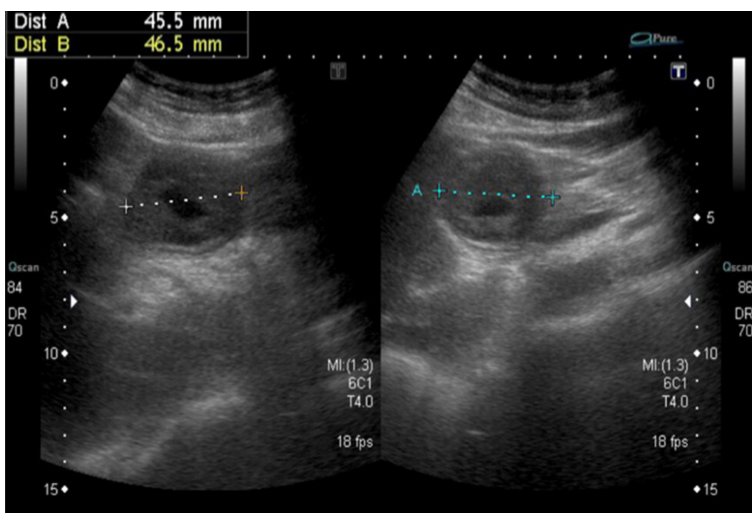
Abdominal ultrasound revealed the doughnut sign, measuring 4.5 cm × 4.6 cm.
